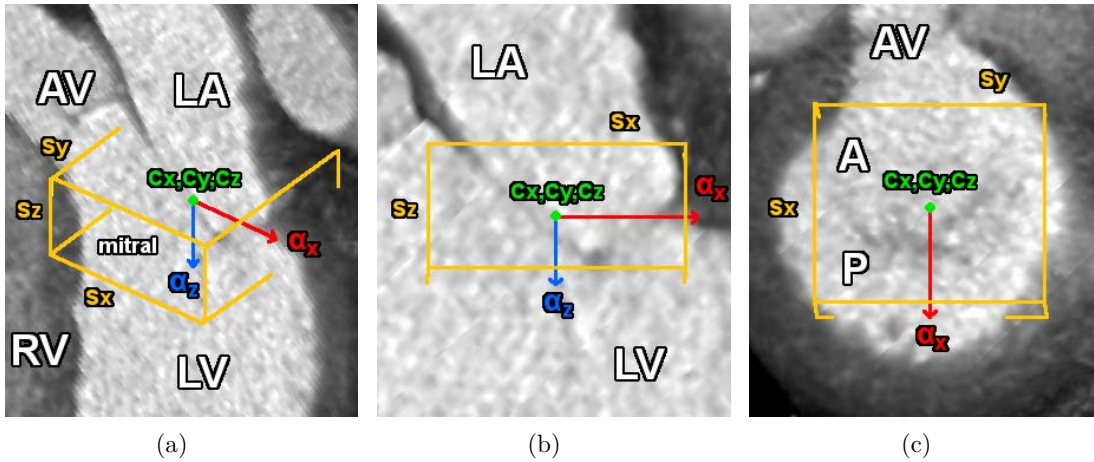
Similarity transform represented as a bounding box around the mitral valve from cardiac CT. (a) Perspective view; (b) Long Axis; (c) Short Axis.
